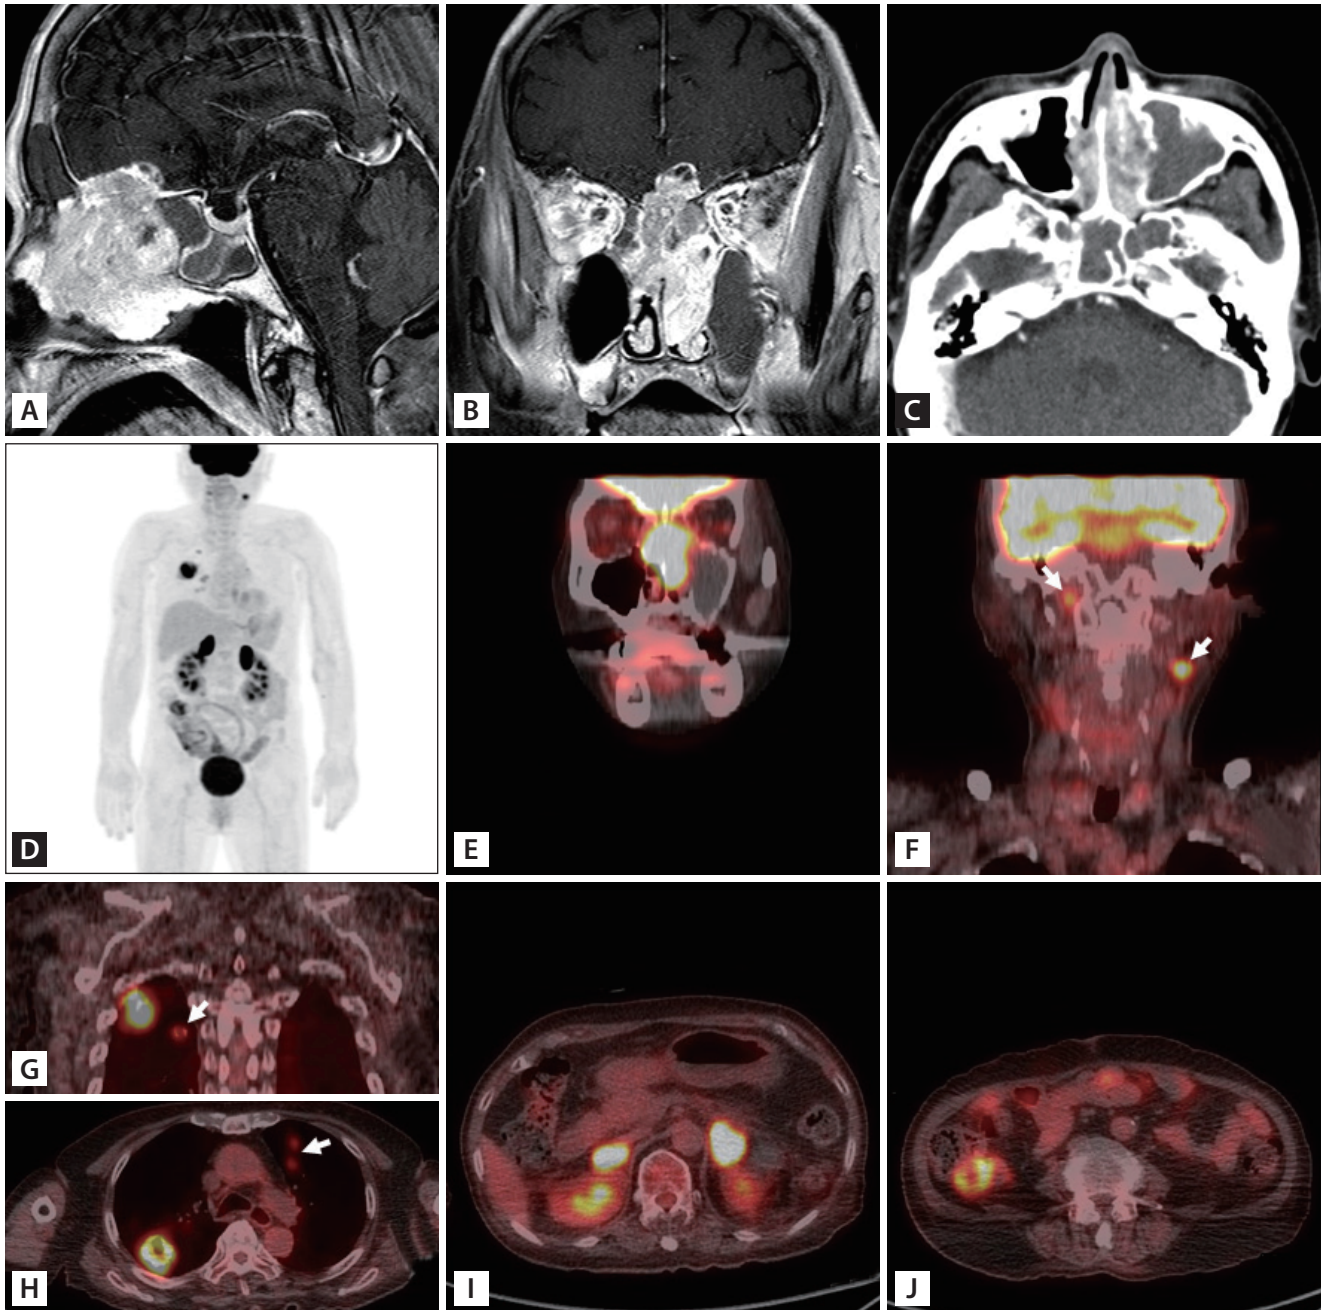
The representative radiologic (magnetic resonance imaging) and 2-[fluorine-18]-fluoro-2-deoxy-D-glucose-position emission tomography/computed tomography (FDG-PET/CT) images. A 4 × 3 × 3 cm heterogeneously enhanced mass occupying both sinonasal cavities with intracranial extension to the anterior cranial fossa. It destroyed the ethmoid bone structure and obstructed the left osteomata unit and pansinusitis (A, B, C). Representative coronal PET/CT images revealed intense FDG uptake at multiple sites (D), including the nasal cavity (E), lymph nodes (F), lung (G, H), adrenal gland (I), and cecum (J). Arrows indicate the FDG uptake in the lymph node in the right retropharyngeal and level II (F) and in the multiple lung nodules (G). FDG uptake was observed in the tumor in the nasal cavity and cribriform plate.
